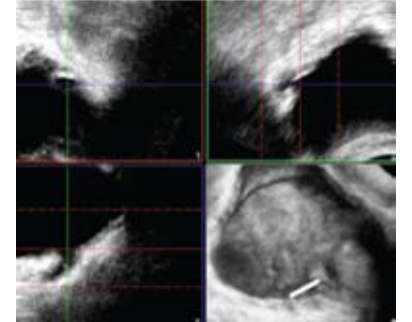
Ultrasound cystoscopy in a 2 year old boy with a duplex left kidney and a refluxing ureter: 2-D images show the lower ureter in different views but the 3-D cystoscopic approach much better demonstrates the pattern of the opened ureter
